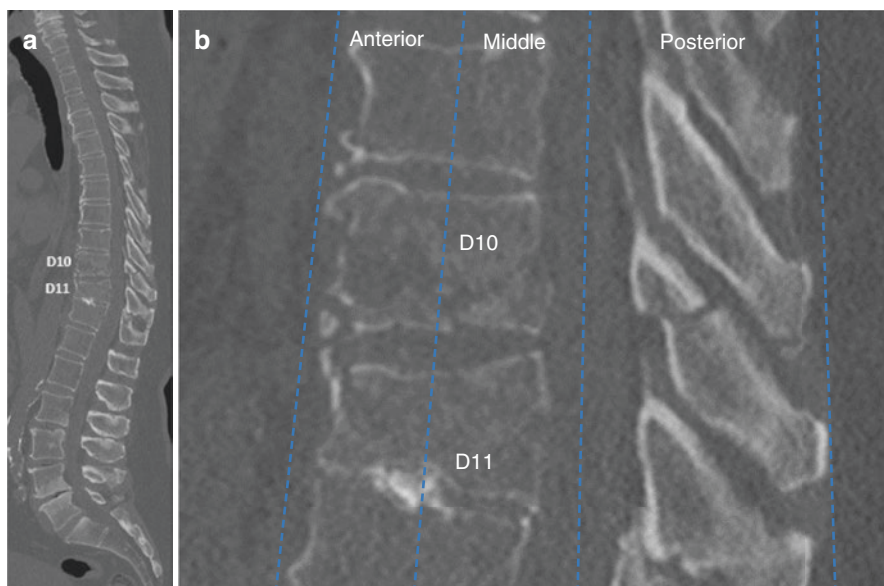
Three column fractures of the spine involving D11 and D10 respectively, on sagittal CT. (a) shows sagittal reconstruction from 3D CT and (b) shows zoomed view of the fractures at D10/11 level
